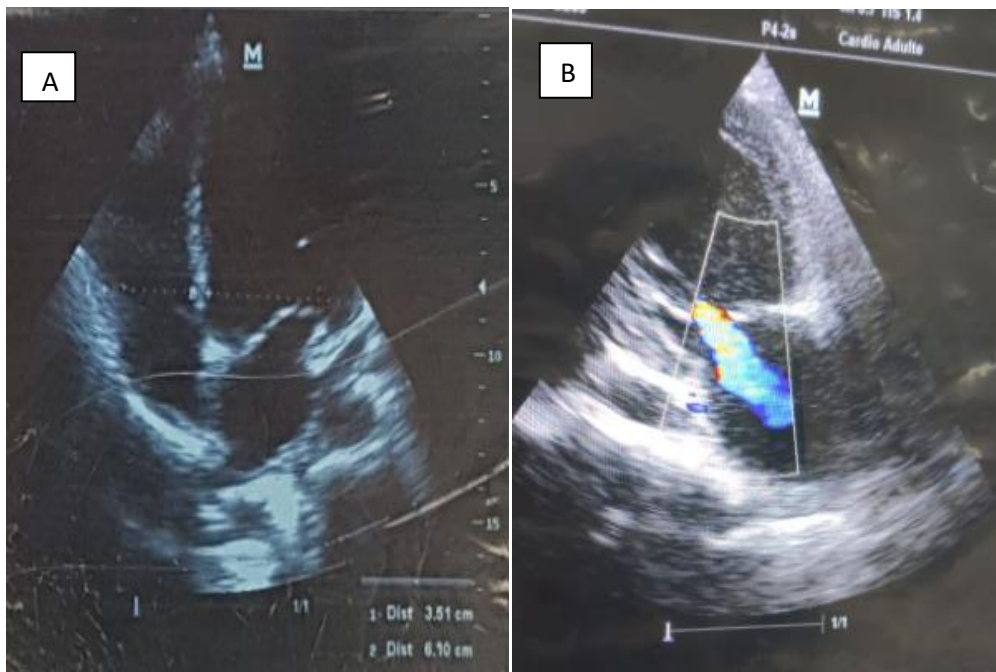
(A) Echocardiography four chamber view showing dilatation of the left ventricle; (B) Echocardiography two chamber view showing moderate mitral regurgitation.
